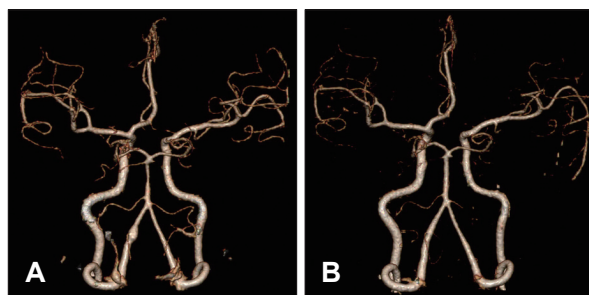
Case 2. A 54-year-old woman with intermittent headache after swimming. A: Initial CTA showing fusiform aneurysm at left V4 segment. B: After 4 months, the aneurysm disappeared completely. CTA: computed tomographic angiography.
